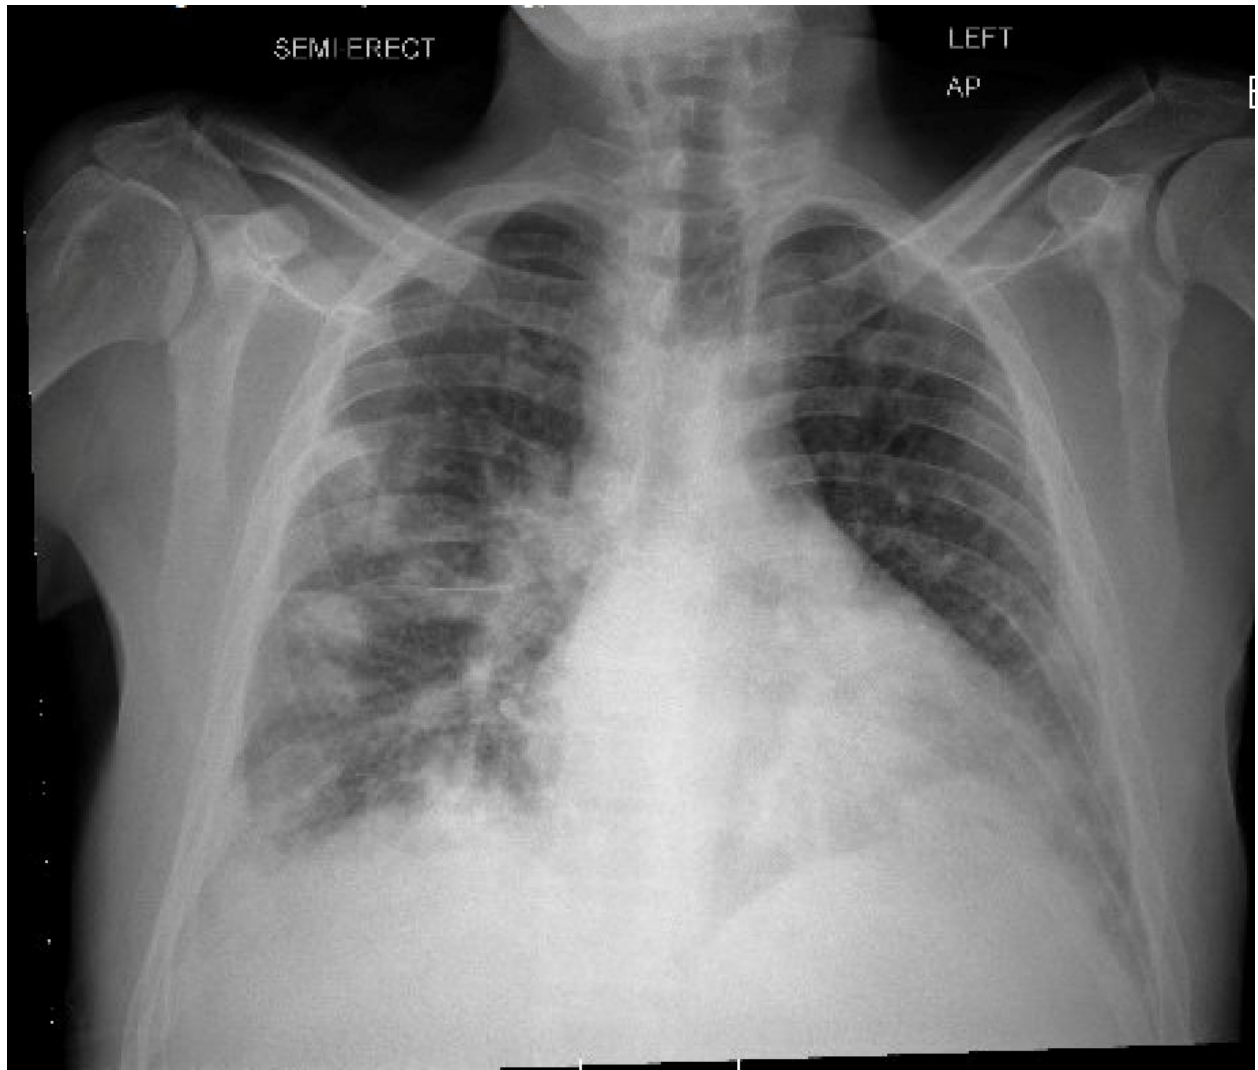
Chest X-ray showing bilateral nodular lung opacifications.
